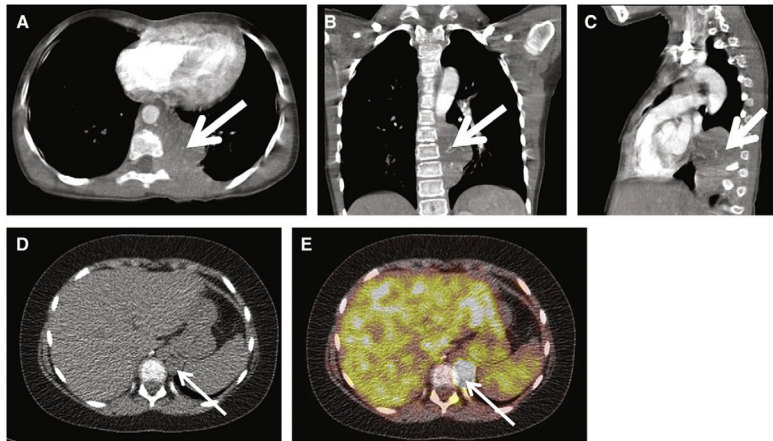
Supradiaphragmatic PGL in a 9-year-old *SDHB*+ girl with a 4-year history of heat intolerance and malaise. *A–C*, Axial, coronal, and sagittal contrast-enhanced CT images, respectively, demonstrate a $5.9 \times 3.5 \times 6.1$ -cm left posterior mediastinal mass (*white arrow*). Invasion of the left T8 neural foramen is demonstrated on the axial image (*A*, *white arrowhead*). Arterial phase CT attenuation of this mass was 52 HU; portal venous phase CT attenuation of this mass was 88 HU. The patient underwent thoracotomy and resection of the posterior mediastinal mass, confirming PGL. *D–E*, at 15 months after resection, FDG PET-CT images demonstrate a new 1.5-cm retrocrural metastasis, with maximal SUV of 34 (*white arrow*) as well as pleural based masses (not shown), consistent with metastases.
